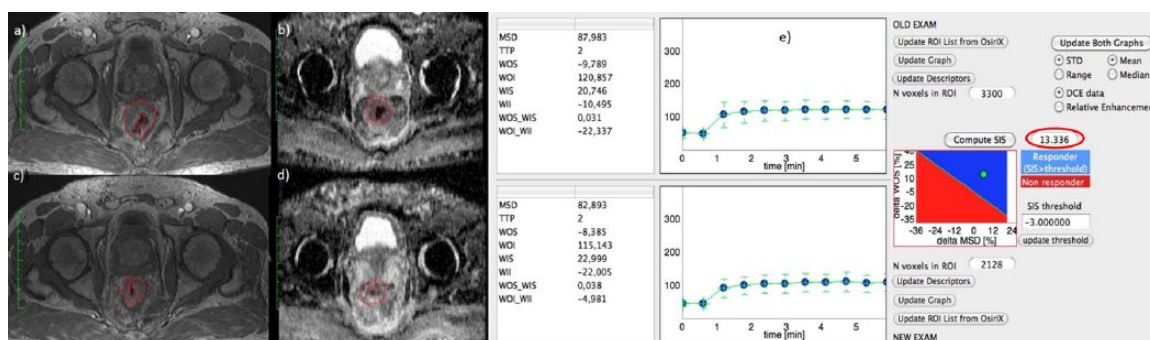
Dynamic contrast-enhanced magnetic resonance images and standardized index of shape analysis for a responder patient with tumour regression grade 2. Figure 2(a), (c) and (e) show DCE-MRI images and SIS analysis for a responder patient with TRG 2 and Δ SIS = 13.34%. For the same patient, Figure 2(b) and (d) show the ADC map pre- and post-treatment. Δ ADC value was 38.79%. ADC, apparent diffusion coefficient; DCE, dynamic contrast enhanced; MRI, magnetic resonance imaging; SIS, standardized index of shape; TRG, tumour regression grade; MSD, maximum signal difference; ROI, region of interest; STD, standard deviation; TTP, time to peak; WII, wash in intercept; WIS, wash in slope; WOI, wash out intercept; WOI_WII, wash out intercept on wash in intercept rate; WOS, wash out slope; WOS_WIS, wash out slope on wash in slope rate.
